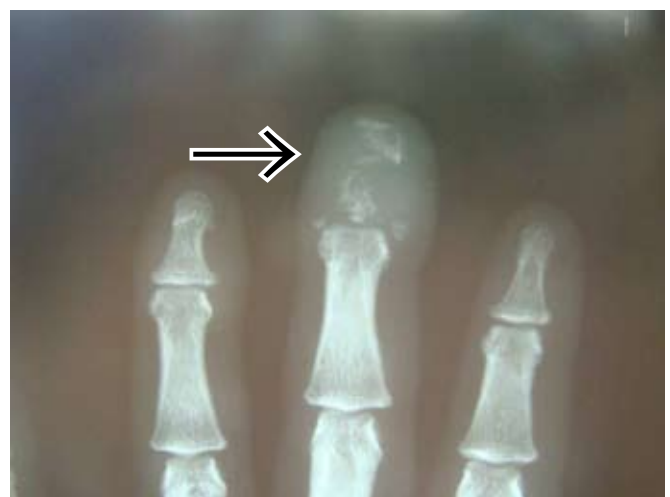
Frontal X-ray of the terminal tufts with acroosteolysis owing to an overlying neurofibroma.
